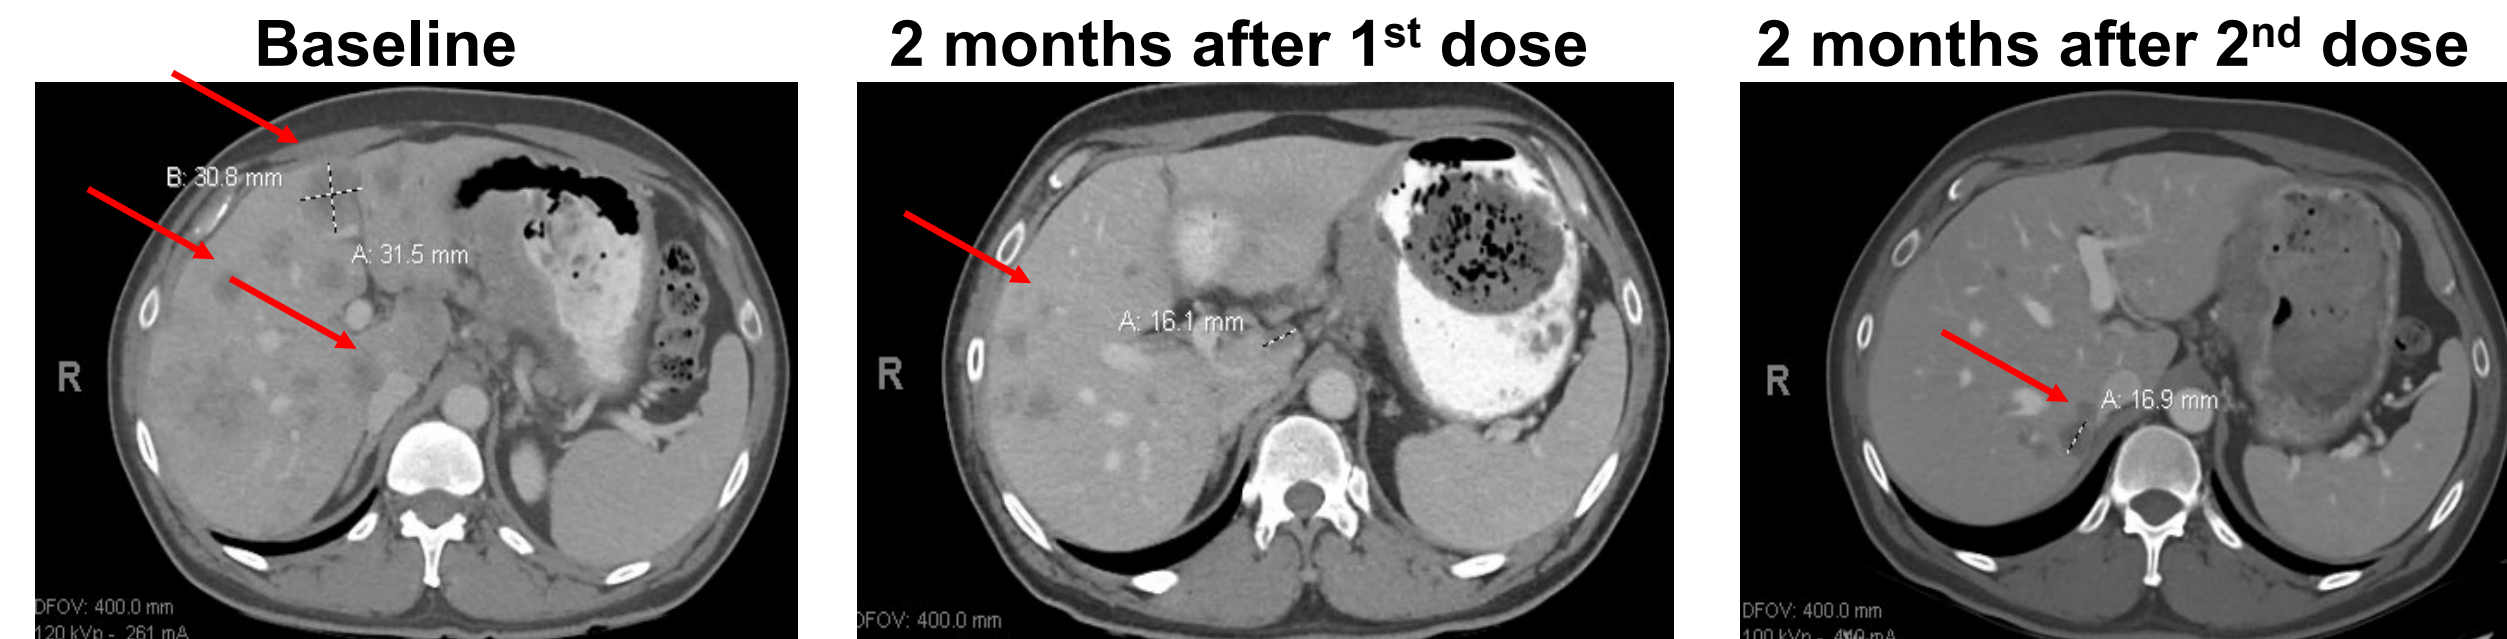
Representative CT scan images for the patient receiving repeated infusions of anti-claudin 18.2 CAR-T cells (CT041). Red arrows: multiple liver lesions.
